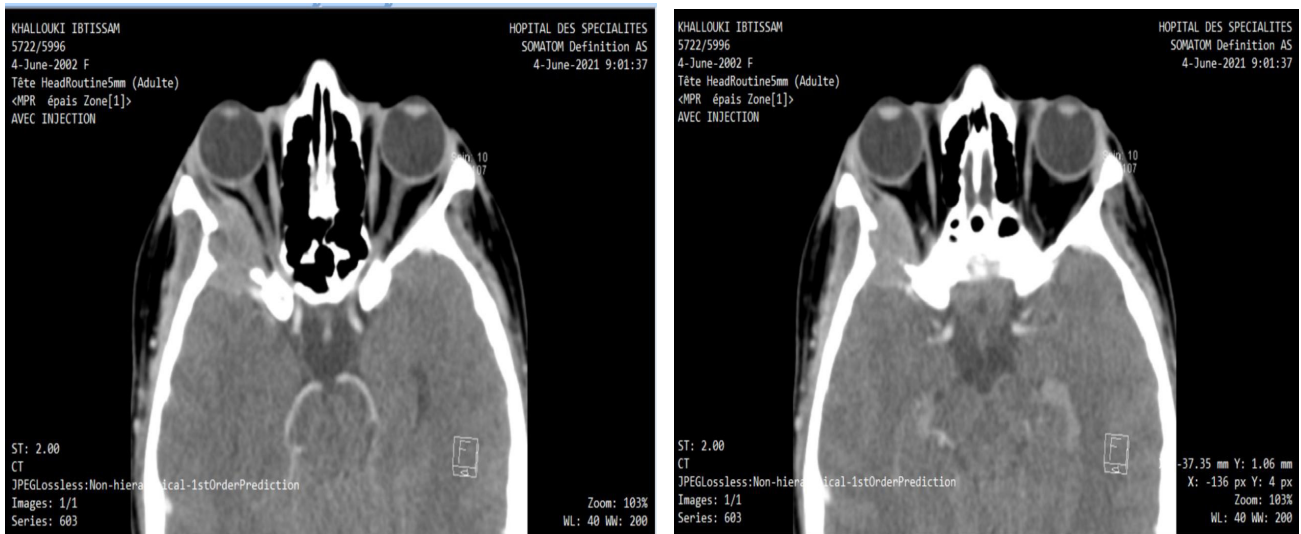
Cross-sections of orbital-cerebral CT showing an extra conical nodular thickening centred on the lateral rectus of the right orbit, associated with sphenoid lysis.
